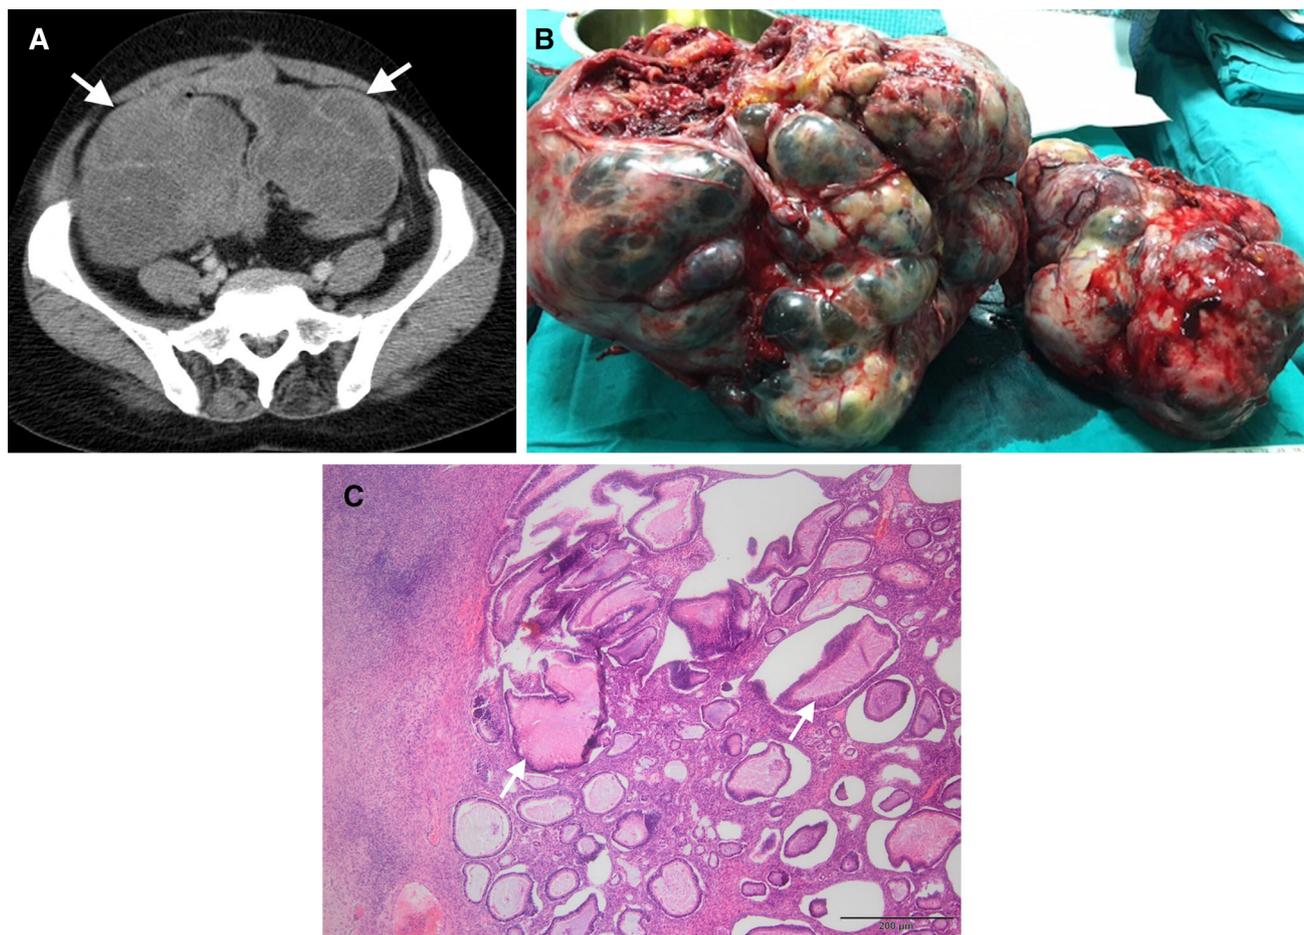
Forty-four-year-old woman with known colon cancer who was treated with surgery and chemotherapy. Two years after the diagnosis the patient presented with progressively increasing abdominal fullness and pain. A Axial contrast-enhanced CT image demonstrates bilateral giant semisolid masses (arrows) in both adnexa. The masses appear to have
